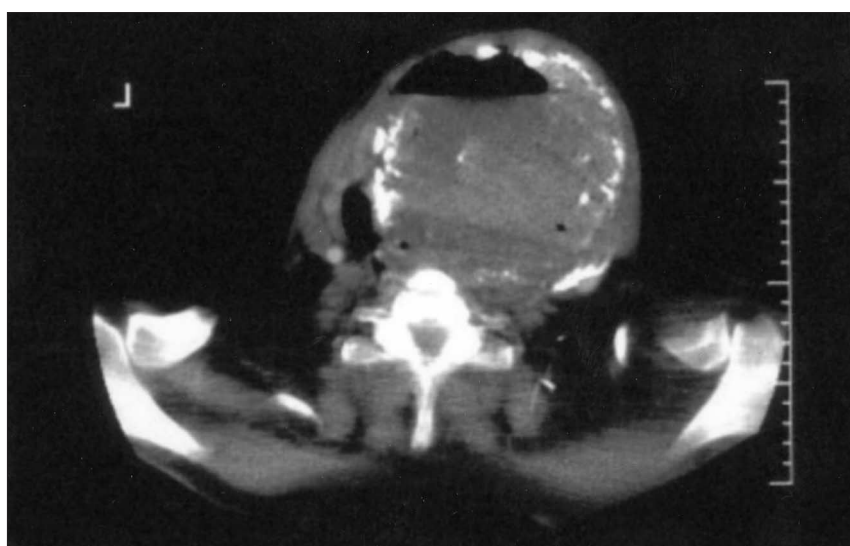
Computed tomography scan of the neck showing air fluid level within the thyroid gland.
